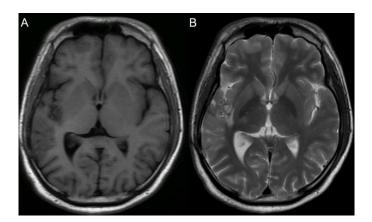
After one year of second operation, MRI images show no mass in the right sylvian fissure: MRI-T1 weighted image, axial view (A), MRI-T2 weighted image, axial view (B).
